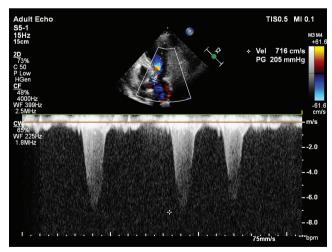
Transthoracic echocardiography color Doppler imaging revealed a 205 mmHg gradient at the left ventricular outflow tract.
